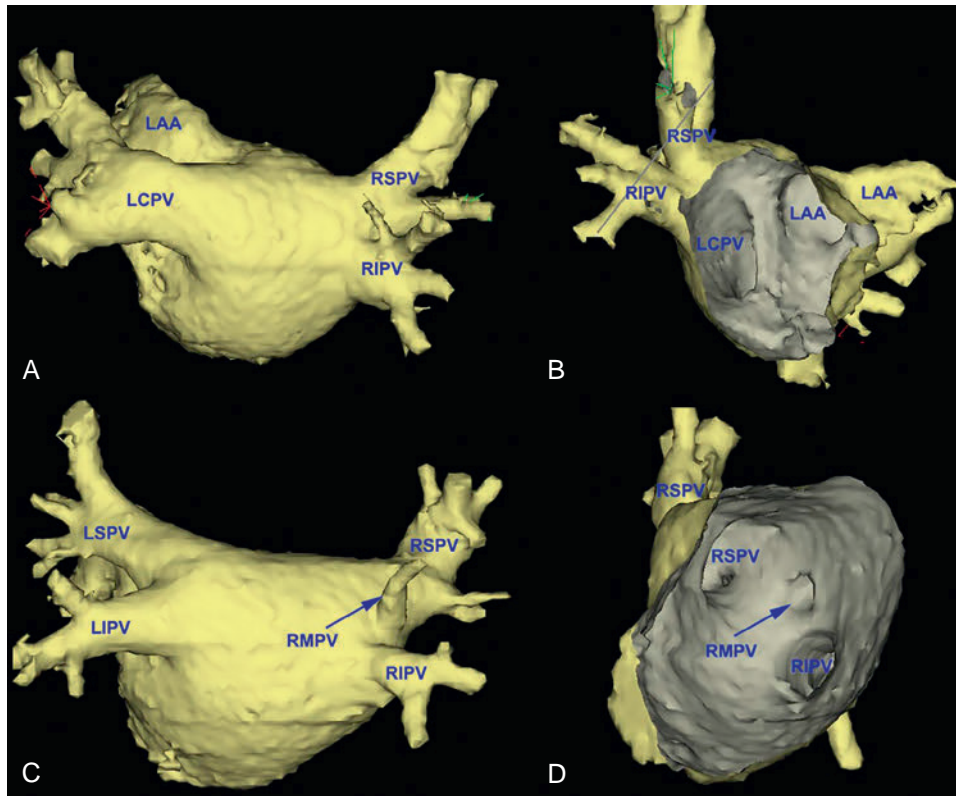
Cardiac Computed Tomography Angiogram (Posteroanterior and Cardioscopic Views) of the Left Atrium and Pulmonary Veins (PVs). (A and B) The left-sided PVs share a common ostium. (C and D) Three PVs are observed on the right side. LAA, Left atrial appendage; LCPV, left common PV; LSPV, left superior PV; RIPV, right inferior PV; RMPV, right middle PV; RSPV, right superior pulmonary vein.
